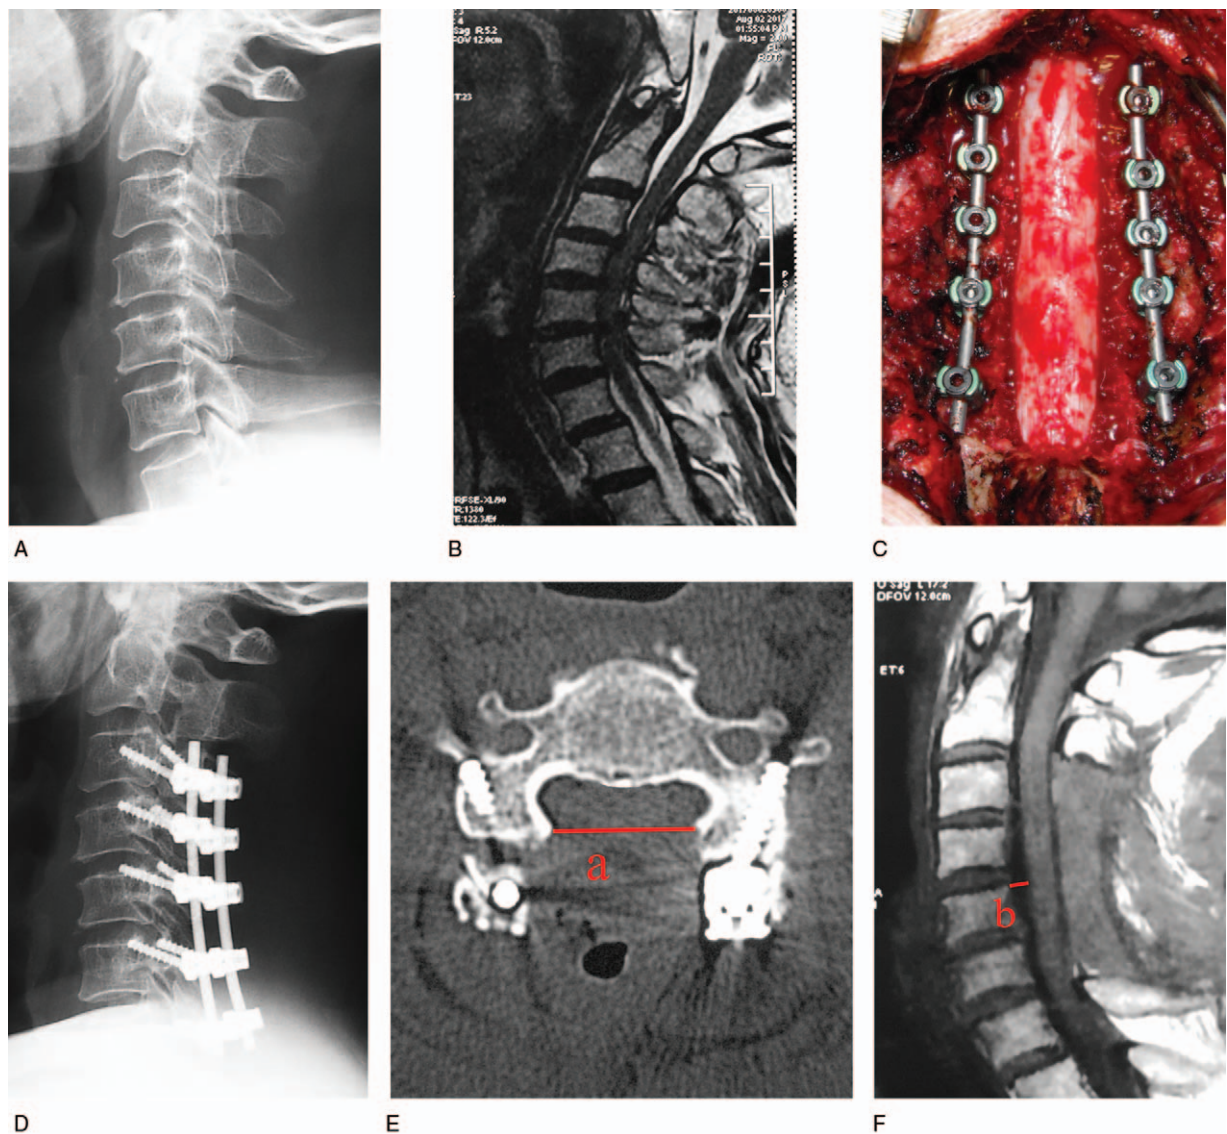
A 60-year-old man with multi-segment cervical spondylotic myelopathy manifesting as an 18-month history of bilateral lower-limb walking weakness. A: X-ray showing mild cervical spine degeneration. B: Overextension magnetic resonance image showing that the spinal cord was compressed anteriorly and posteriorly at C3–7. C: The spinal cord was decompressed using normal laminectomy with fixation. D, E: The cervical curvature index was well maintained during follow-up with a 22.3-mm laminectomy width at C5 level. F: Magnetic resonance image showing a 3.7-mm drift distance of the spinal cord at C5.
